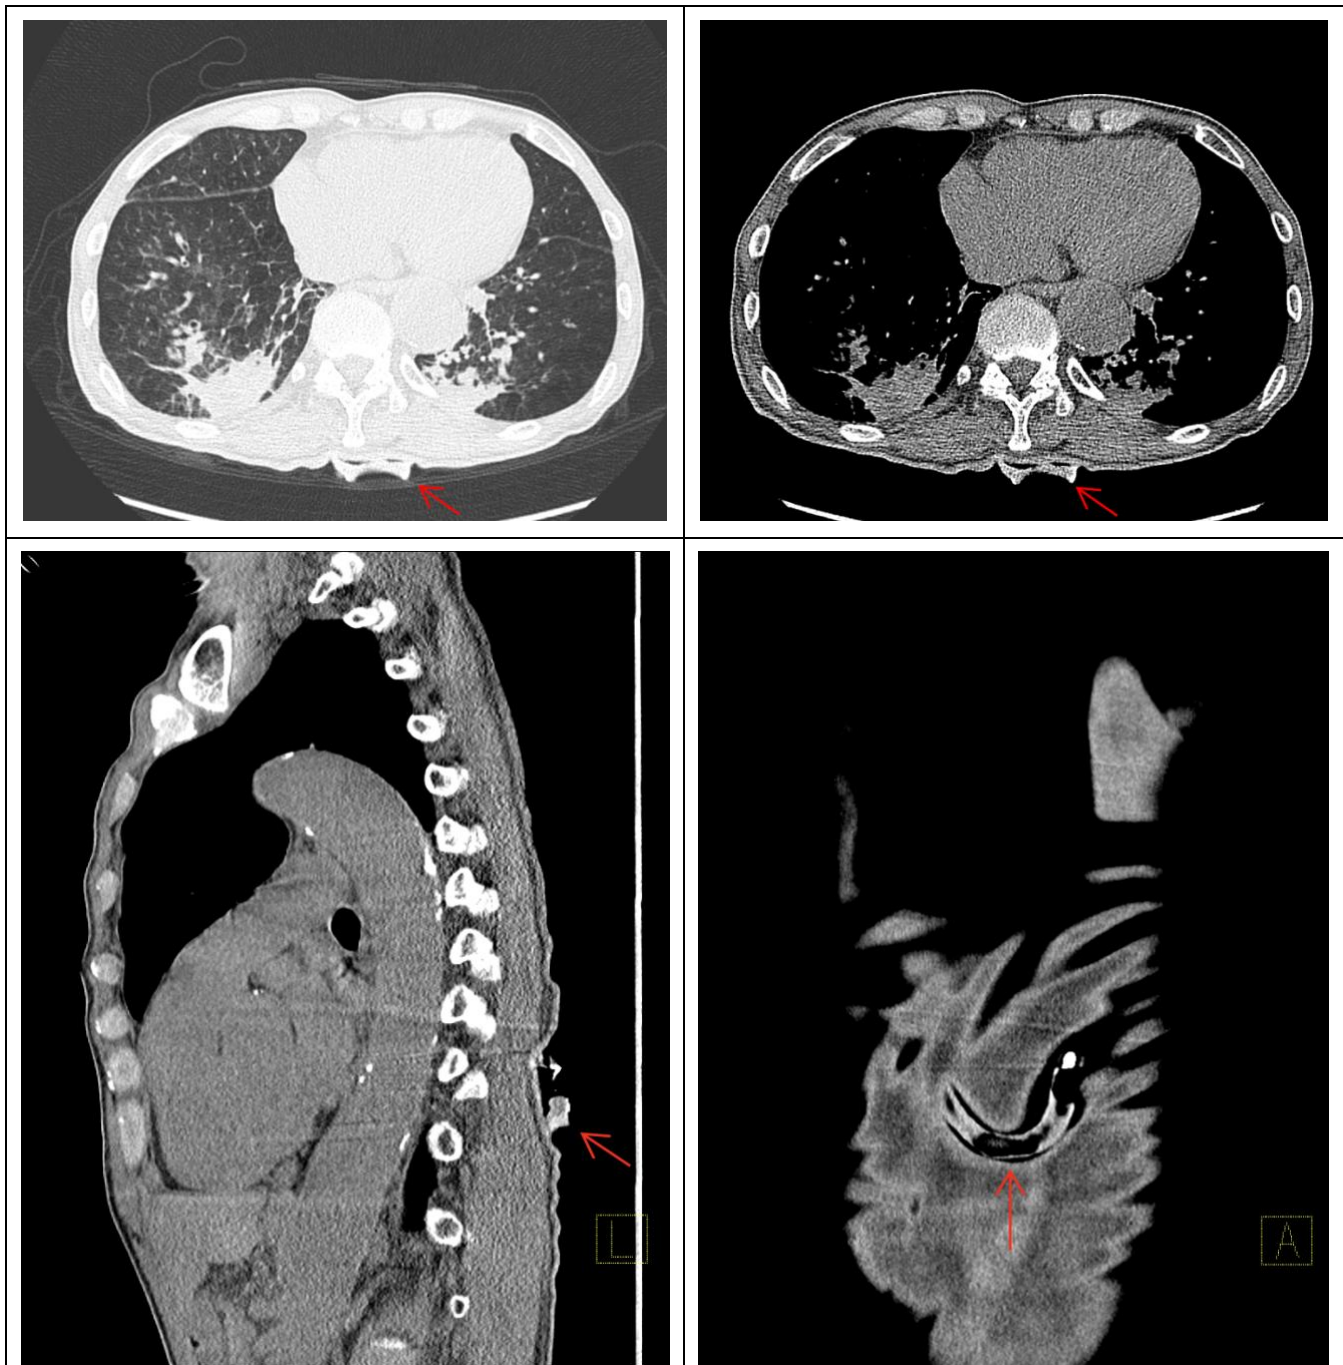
Chest computed tomography demonstrates bilateral pulmonary consolidations suggestive of pneumonia and the denture adherent to the dorsum of the patient (red arrows).
